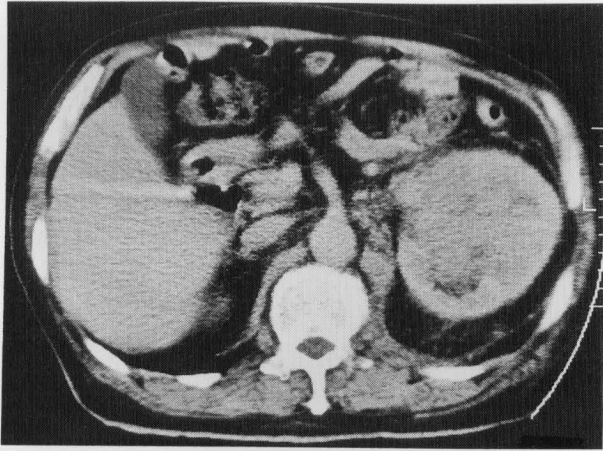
A post contrast CT scan demonstrates a large, inhomogeneous, low-density mass replacing the left kidney.
